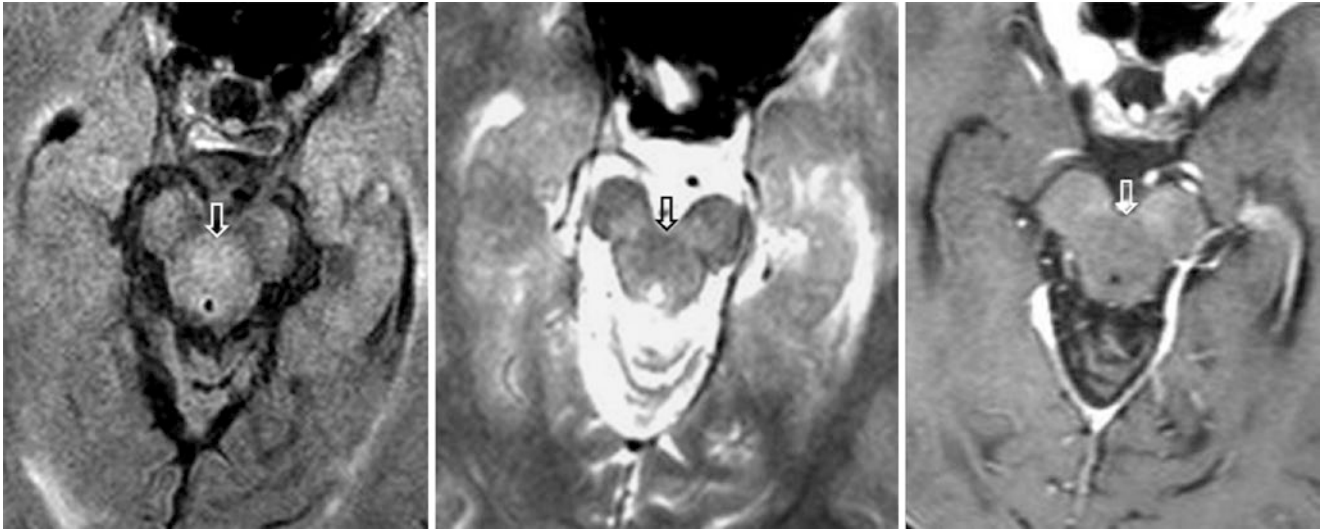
In a 77-year-old with a 1.5 T MRI, axial FLAIR (*left*) shows that the DSCP (*open arrows*) appeared mildly bright, but was slightly dark on T2WI (*middle*), and unremarkable on postcontrast T1WI (*right*). These images are an example of how the DSCP may
